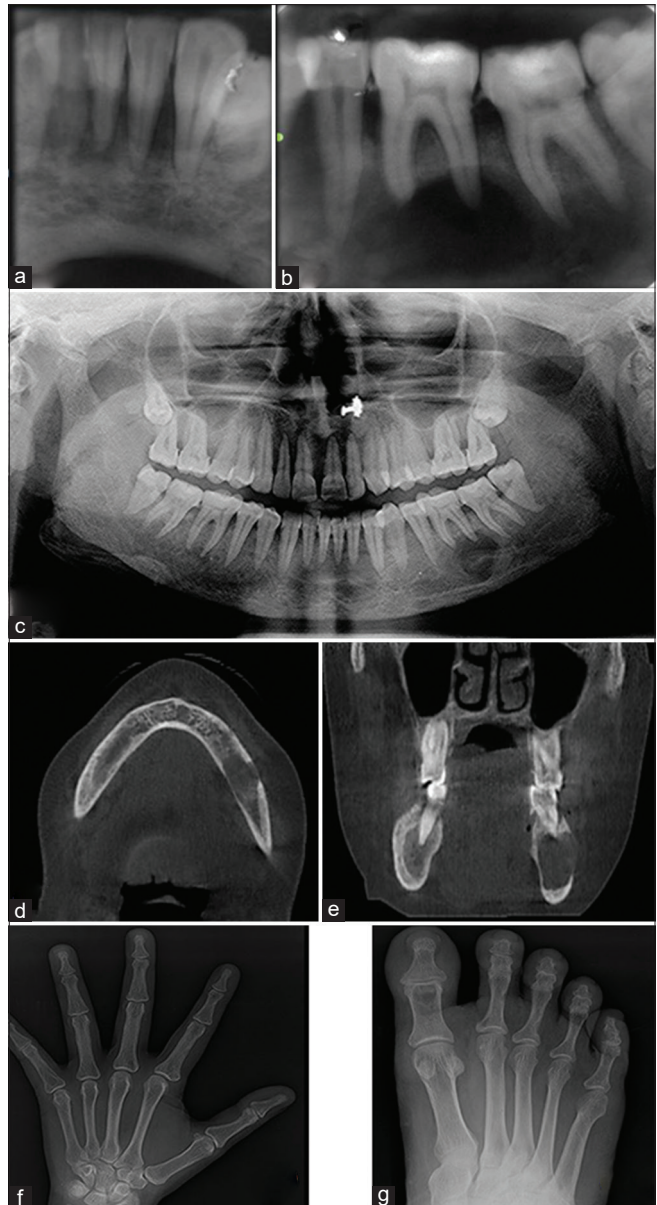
(a and b) Intraoral periapical showing non traceable lamina dura and an ill-defined radiolucent lesion (c) orthopantomogram showing well-defined radiolucent osteolytic lesion with generalized loss of lamina dura. (d and e) Cone beam computed tomography showing osteolytic areas in the mandible causing perforation (f and g) hand wrist and foot radiograph showing osteolytic lesion
